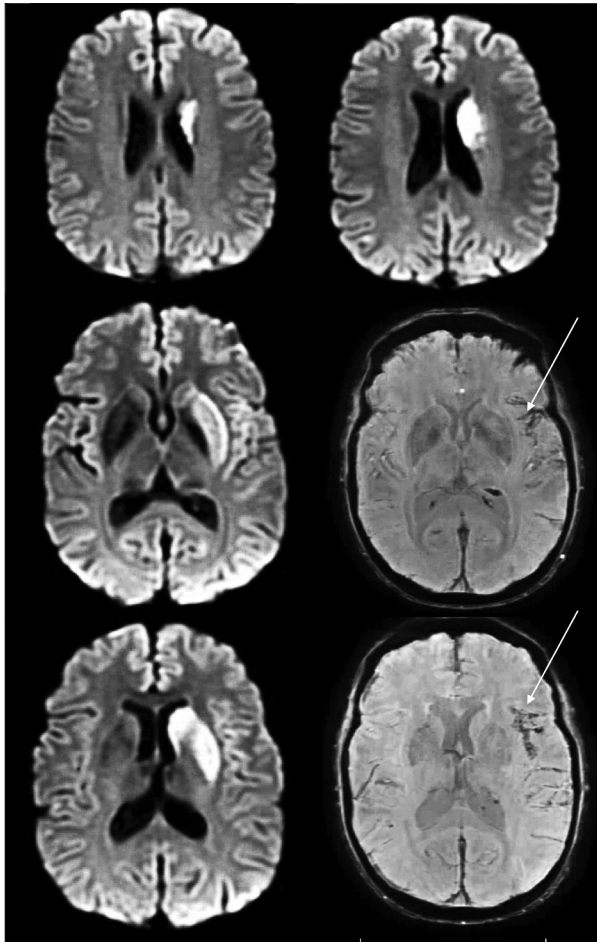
DWI and SWI images showing left caudate and basal ganglia infarcts with minimal subarachnoid hemorrhage (white arrows) in Sylvian fissure post embolectomy. DWI: diffusion-weighted imaging; SWI: susceptibility weighted imaging
